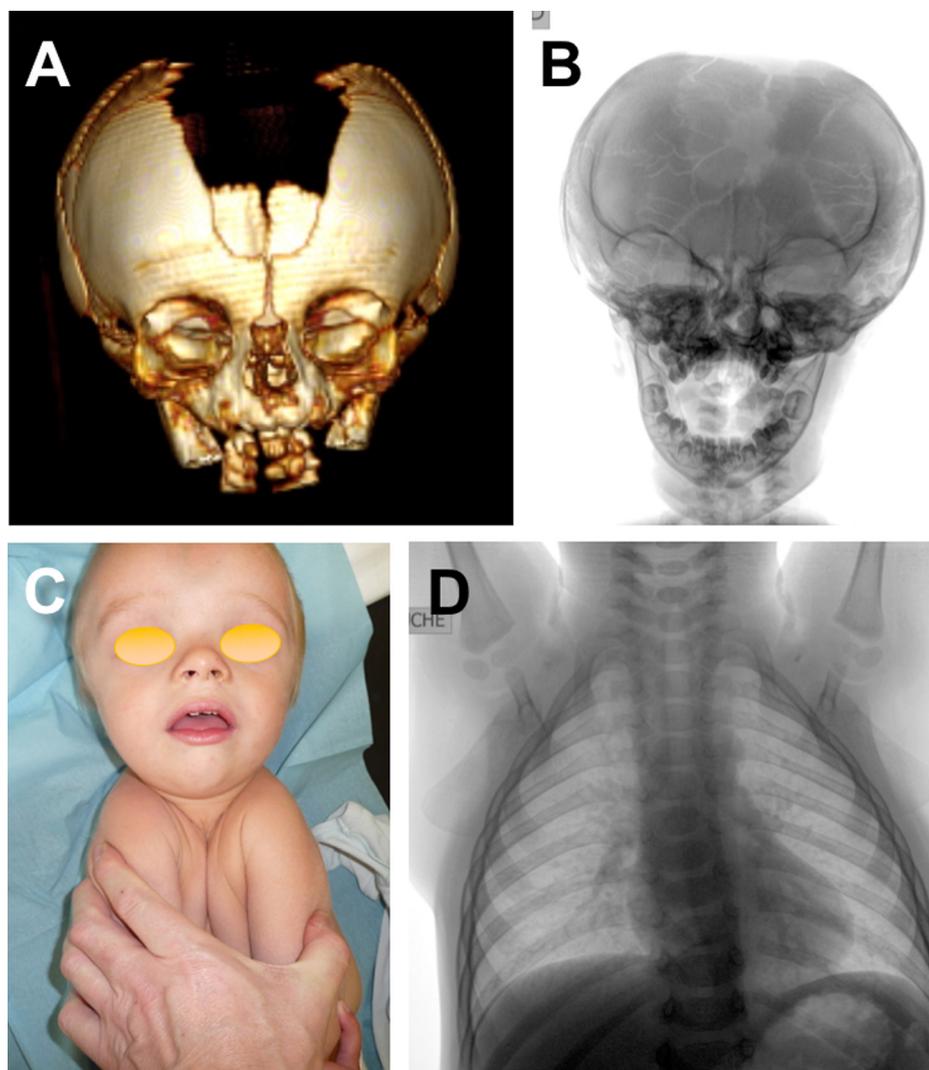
Child affected with cleidocranial dysostosis, with very large anterior fontanel extending from the nasion, and “kissing shoulders” on account of severely hypoplastic clavicles. A. CT scan, aged 6 months. B. Skull X-ray, aged 26 months. C. The child aged 26 months. D. Thorax X-ray, aged 28 months.
